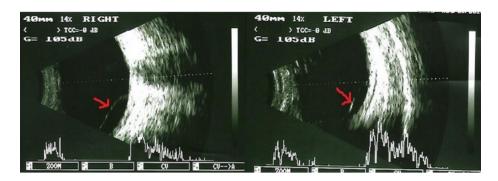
B-scan of ultrasound examination showing the retinal detachment in both eyes
